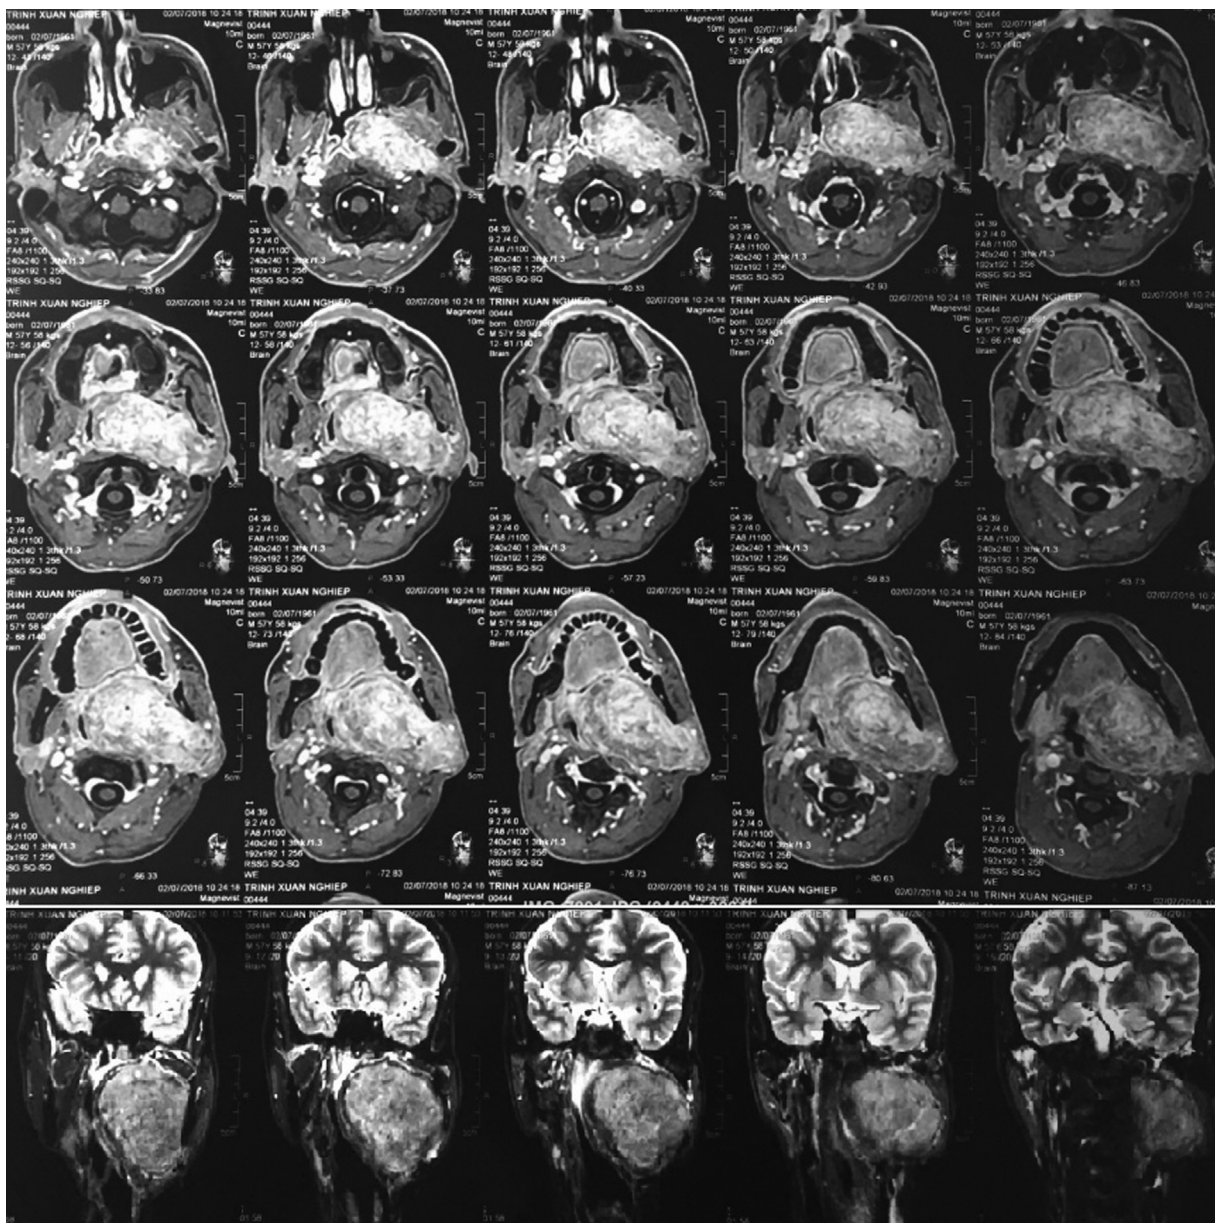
The MRI of the neck and oral cavity.
